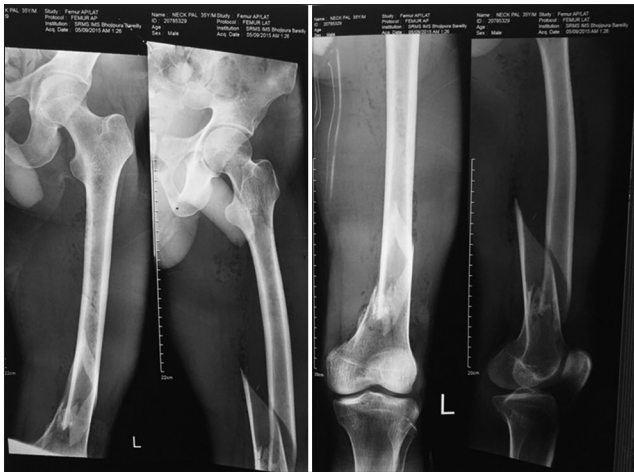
Case 1 - Pre-operative X-ray
